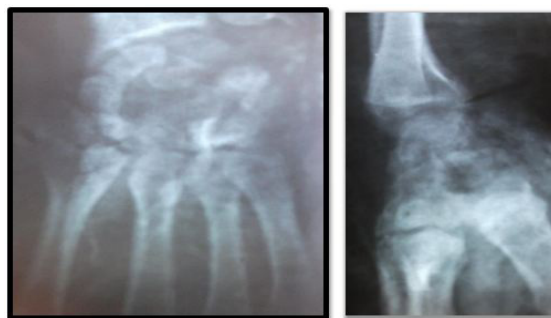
Right wrist post- operative X-Ray the capitate head was totally enucleated and no ostosynthesis for the scaphoid.
